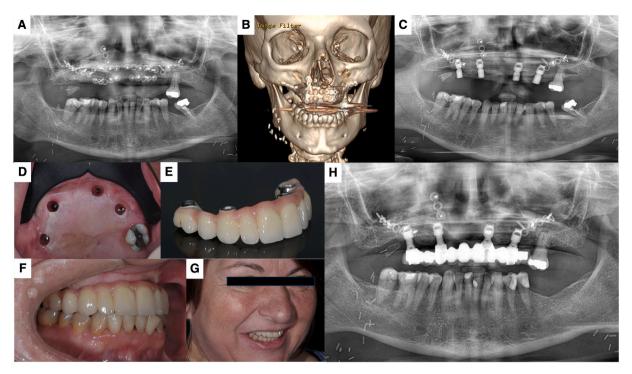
Representative case of maxillary fibula flap. A) Panoramic radiograph and B) CT scan of a 52-year-old female patient with squamous cell carcinoma of the premaxilla and hard palate with revascularized fibula graft stabilized by several mini osteosynthesis plates and screws. C) Panoramic radiograph taken after implant surgery, after the placement of healing abutments. D) Photograph taken after the implants were uncovered, and before healing abutments were inserted. E) The prosthesis, which was fabricated using a FRC framework. F) Photograph of the prosthesis at the time of initial loading. G) Photograph and H) radiograph of the patient at the time of initial loading.
